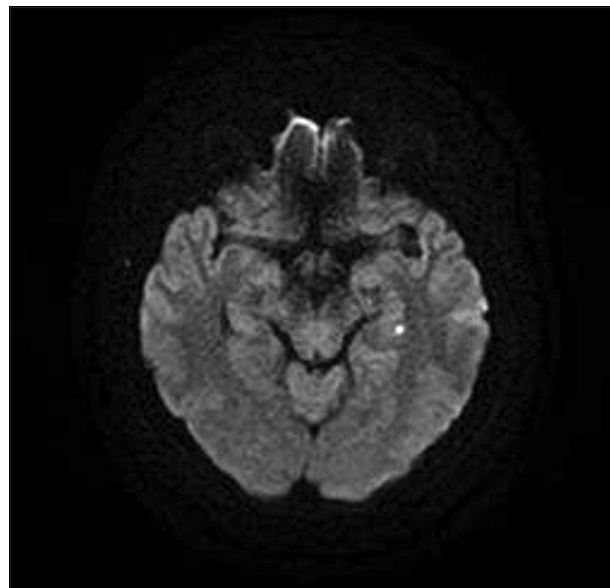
Acute ischemic lesion in the left hemisphere (diffusion-weighted imaging sequence of magnetic resonance imaging)
